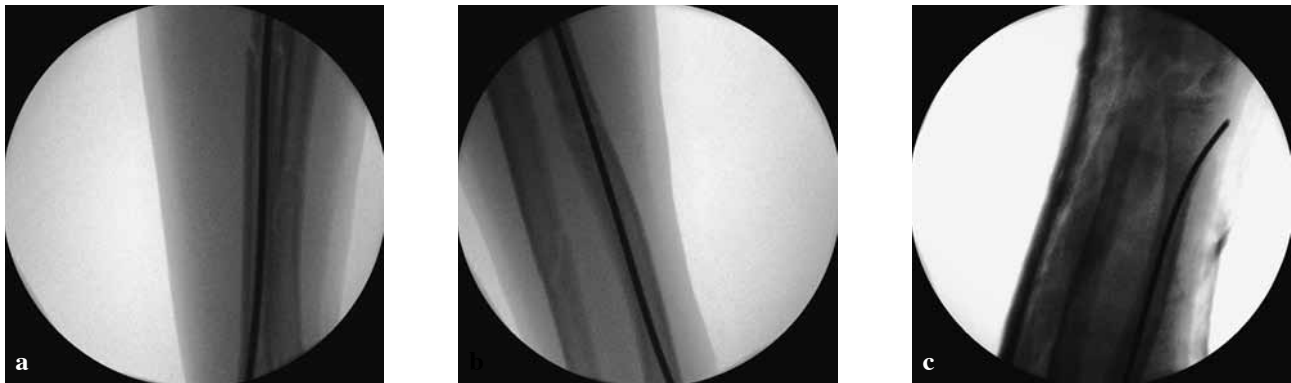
Intraoperative radiographs
